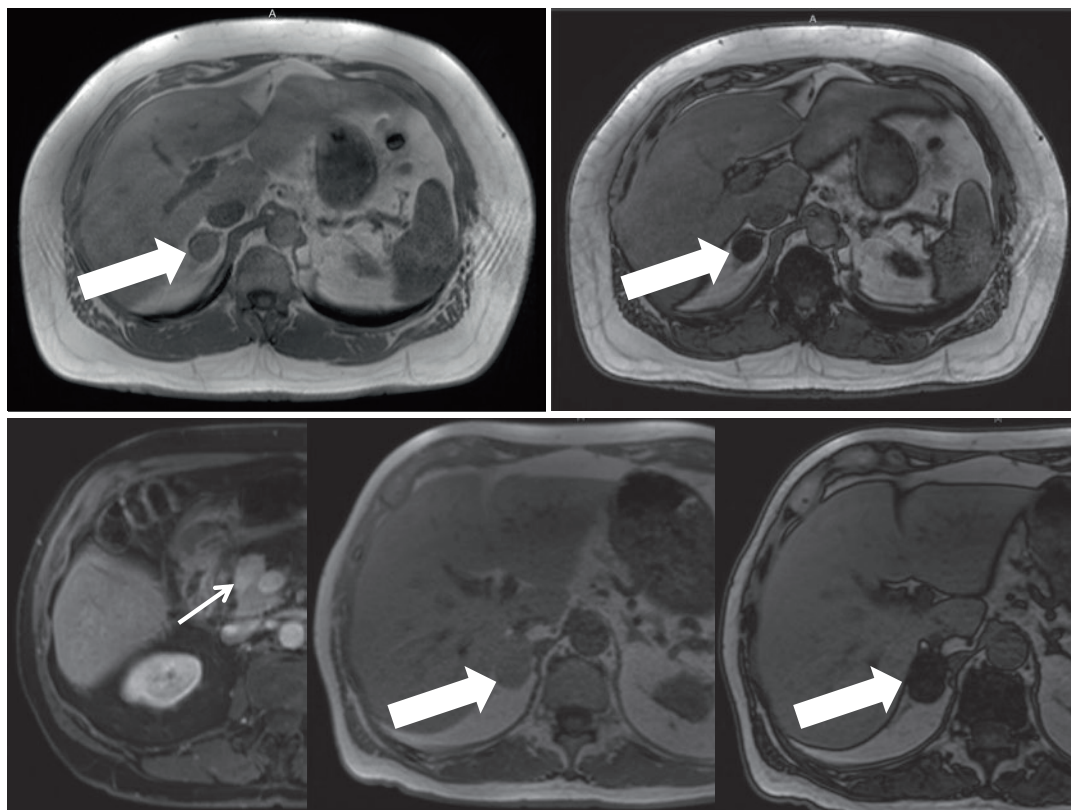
The upper row shows In -(*left image*) and Opposed (*right image*) phase imaging of a participant in a population-based MRI study. The *arrows* point at an incidental adrenal adenoma. The images in the bottom row
